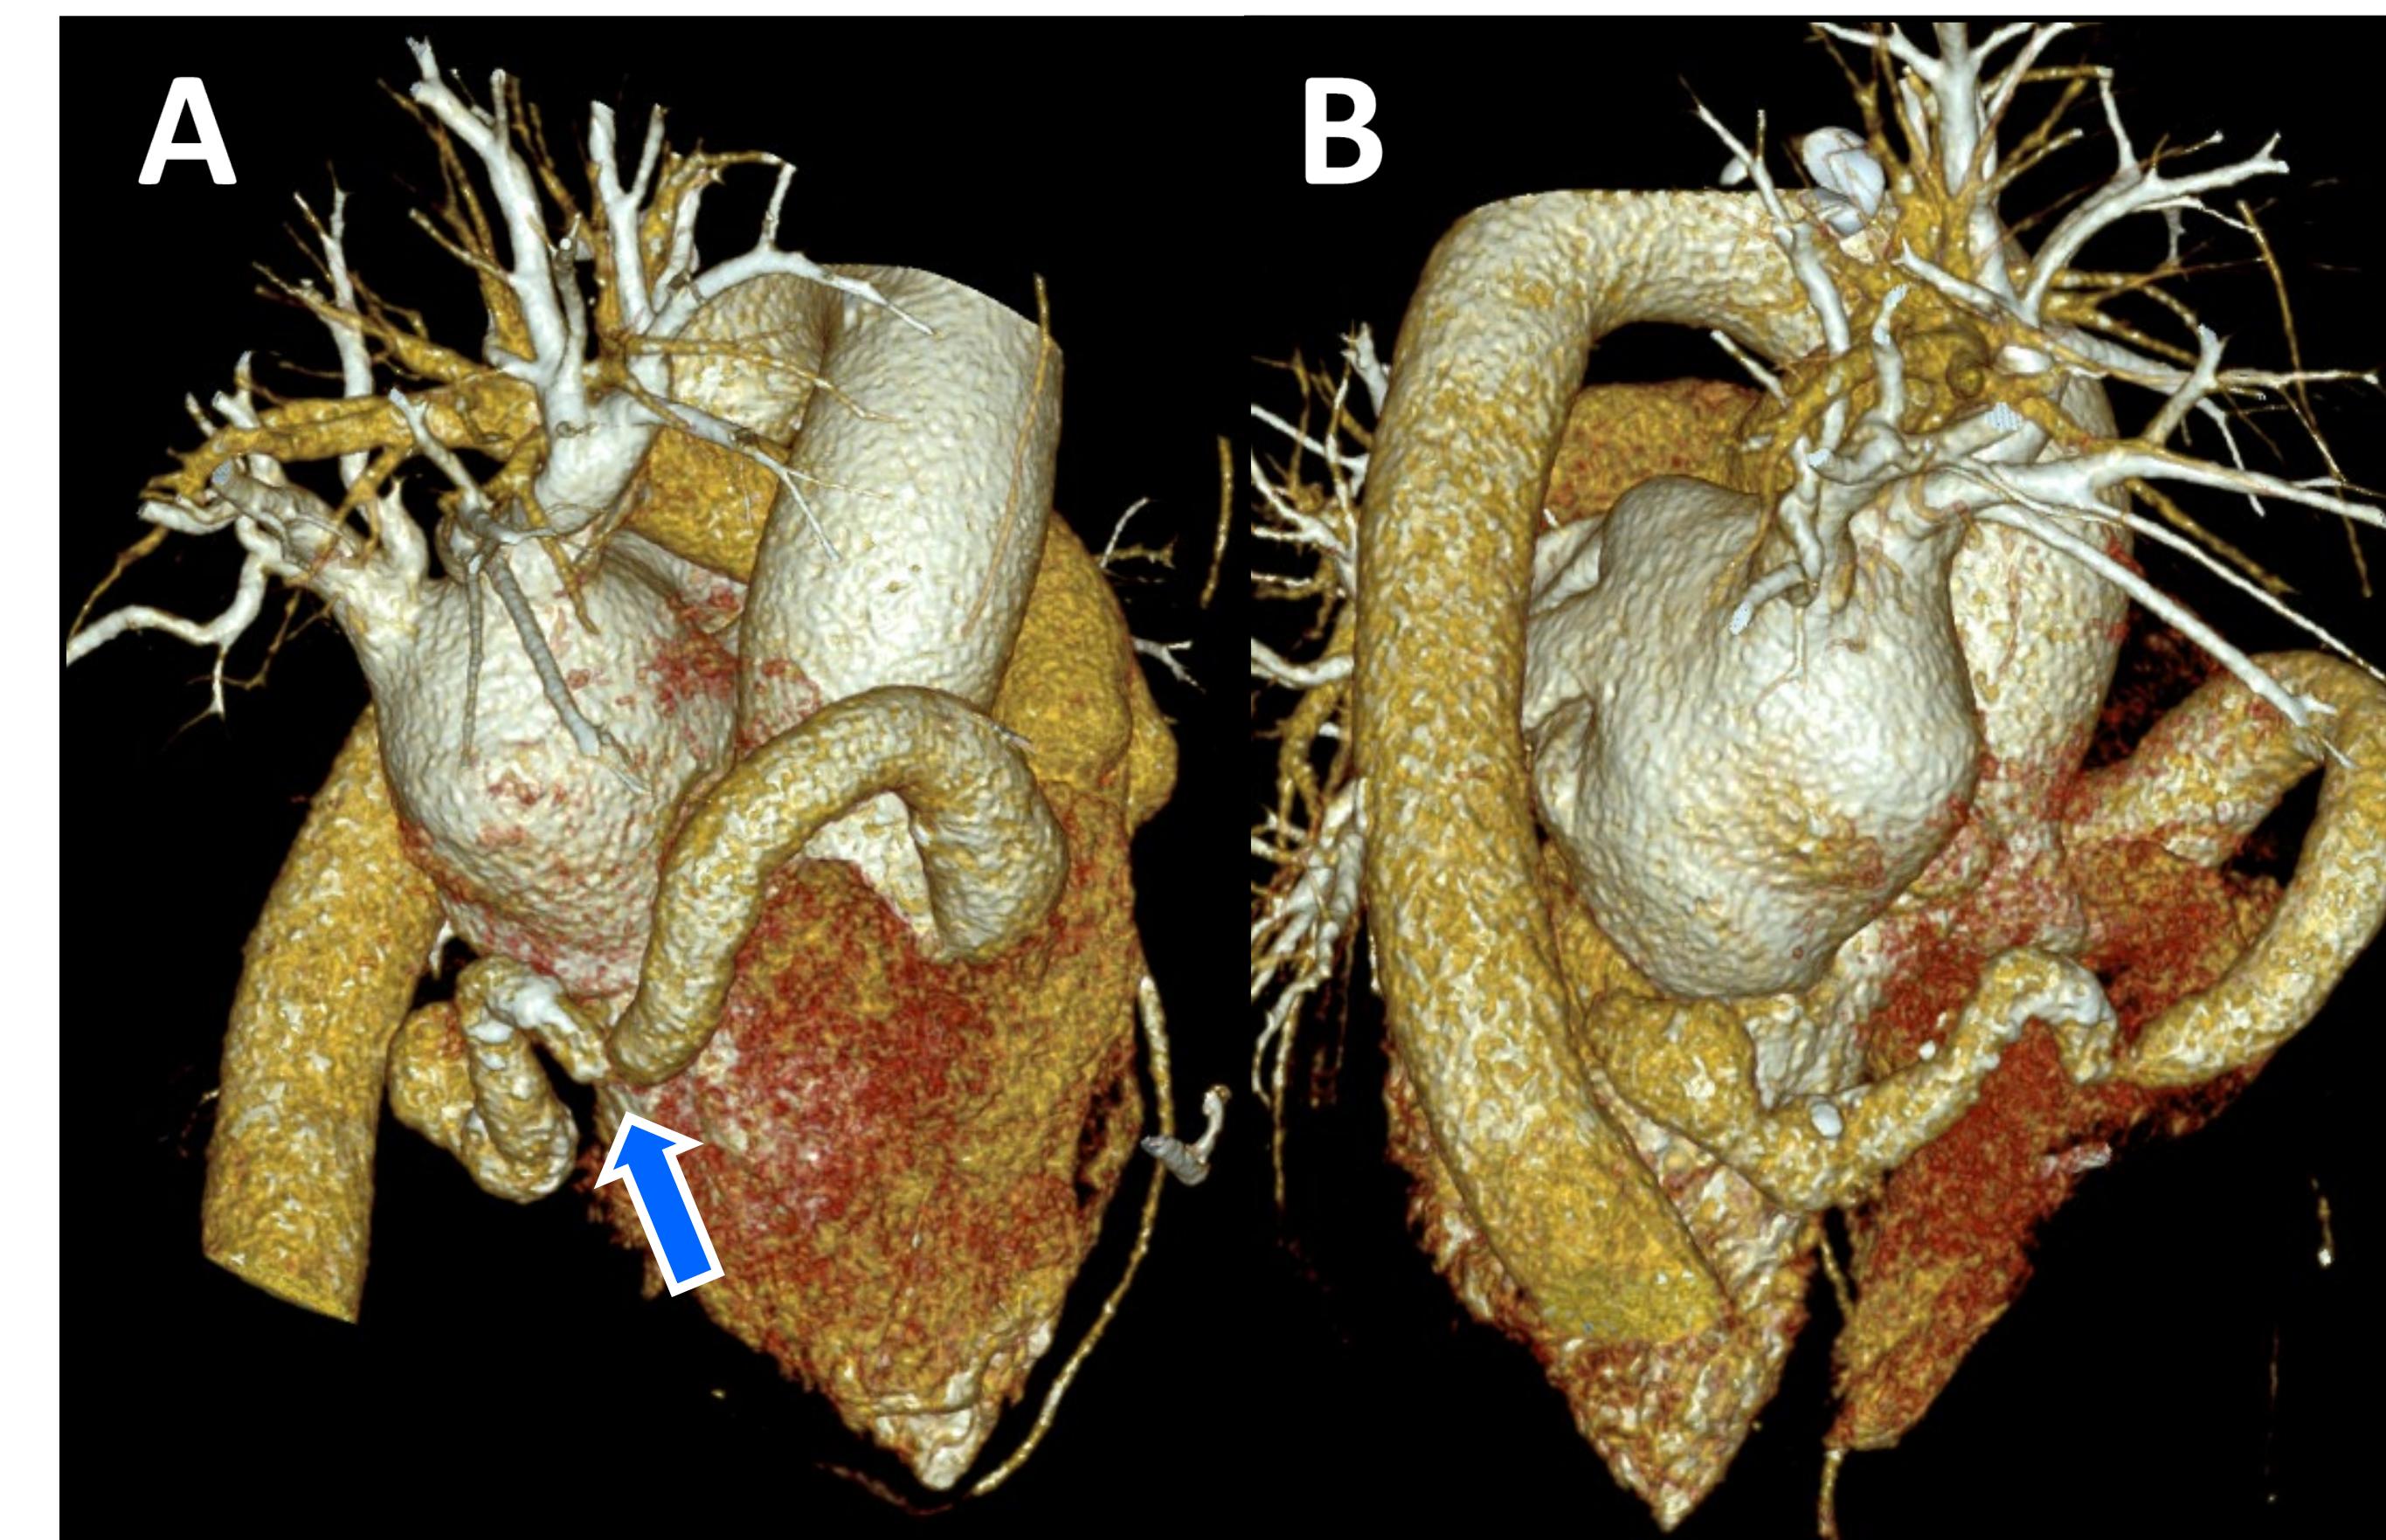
Three-dimensional reconstruction cardiac computed tomography images with aneurysm RCA from the coronary ostium (A) to its insertion in the left ventricle (B). A focal stenosis at the previous ligation in the distal RCA (blue arrow).
